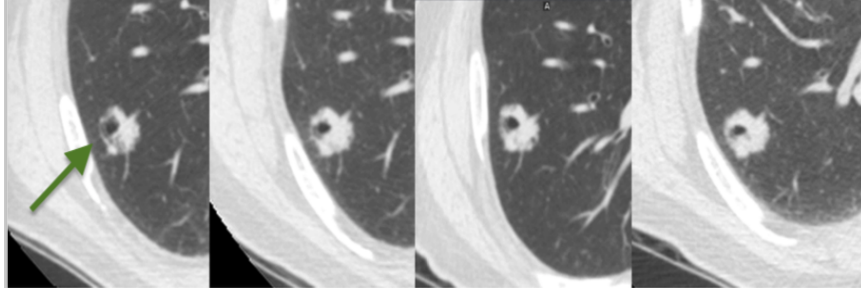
Patient 4: Four CT image recordings of a suspicious nodule spanning 471 days (arrow).
